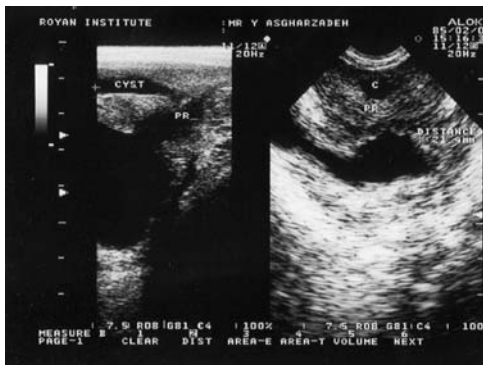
Transrectal ultrasound scan of the cystic lesion in middle portion of prostate (Transverse image and longitudinal image)
